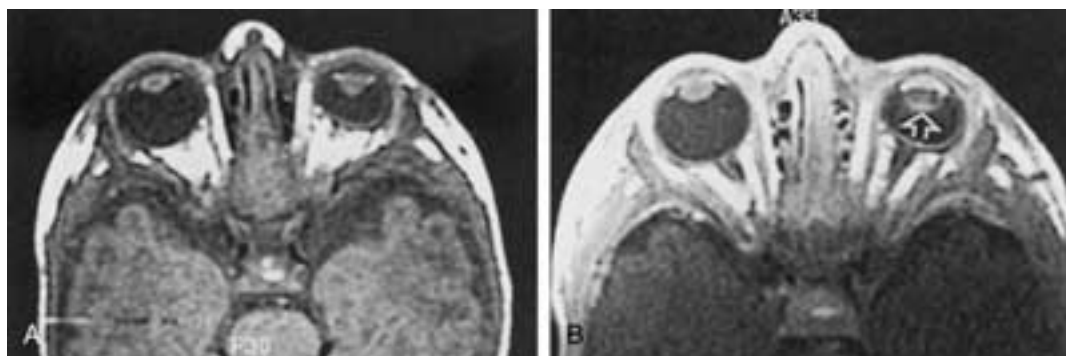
PHPV. Axial Precontrast (A) and postcontrast (B) T1-weighted (450/15, TR/TE) MR images show a microphthalmic left eye. Note the abnormal signal of the left lens, the retrolental enhancing mass (arrow), and the increased enhancement in the left anterior chamber related to elongated ciliary processes, possibly caused by leaking vessels.
